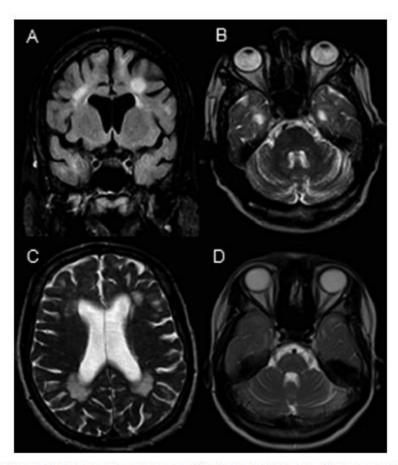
Imaging findings. Coronal FLAIR (A), axial T2-weighted images (B, C, D) belonging to 2 patients. A-C: First patient. Note moderate cerebral subcortical and cerebellar atrophy; symmetrical, confluent periventricular, and subcortical hyperintense signal changes in cerebral white matter. D: Second patient. Note modest portine and cerebellar atrophy.
